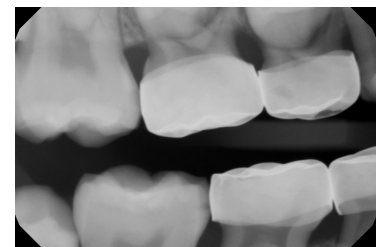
9/2015 radiograph.
